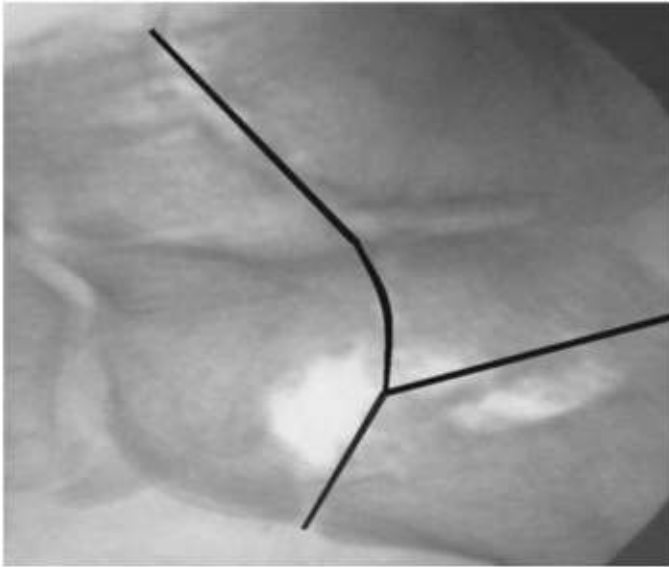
Intra-operative radiograph of the Y-osteotomy. The left side of the Y is the Talar neck osteotomy, the right side of the Y is the calcaneal osteotomy below the subtalar joint and the stem of the Y osteotomy is located at the distal calcaneus.
